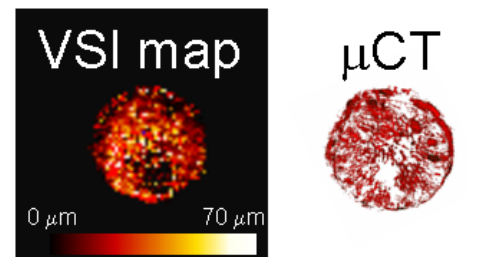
Comparison of MRI vessel size index map with μ CT surface rendering for one representative tumor slice.
